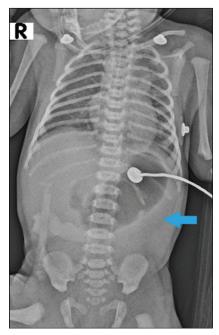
X-ray abdomen with double bubble sign
